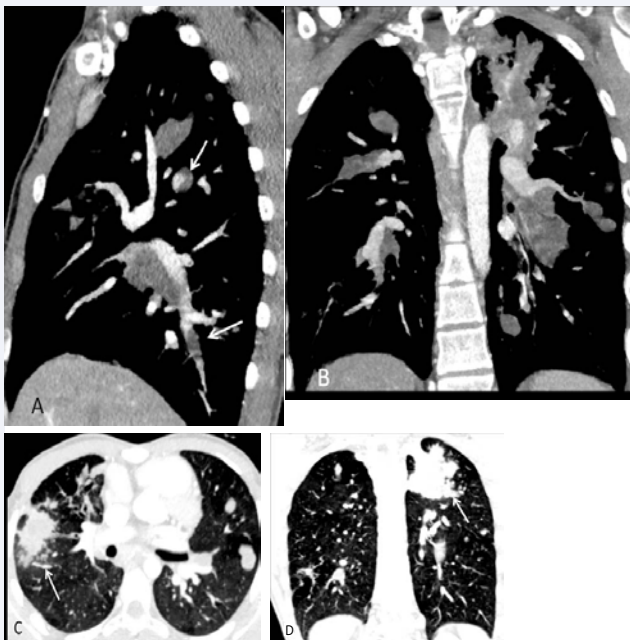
January 2017, Sagittal (A), coronal thoracic CT scan (B) showing persistence of multiple bilateral parenchymal hydatid cysts and chronic pulmonary proximal and distal emboli. Note in parenchymal window (C) and (D) bilateral pulmonary condensation secondary to cysts infection (arrows).
